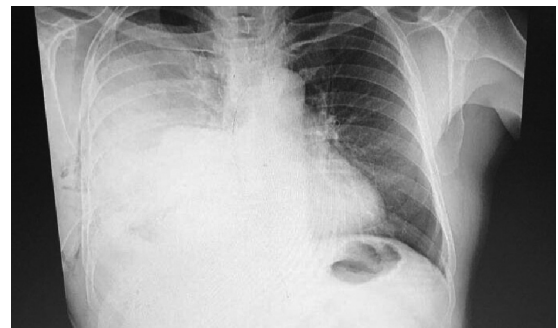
Chest radiograph, blunting of the right costophrenic angle, consolidation, and opacities in right lower lobe (RLL) in the right lung.
